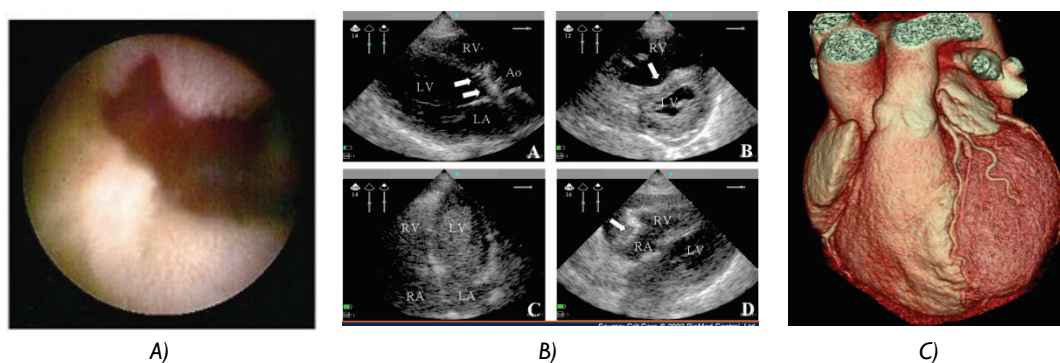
Wireless endoscopic capsule is used to produce videos of the inner bowel and detect problems, such as bleedings (A). Cardiac imaging requires high-performance tools especially for video based modalities such as Echocardiography (A) and 64-Slice CT scans (C, from Upenn Medicine<sup>1</sup>).
